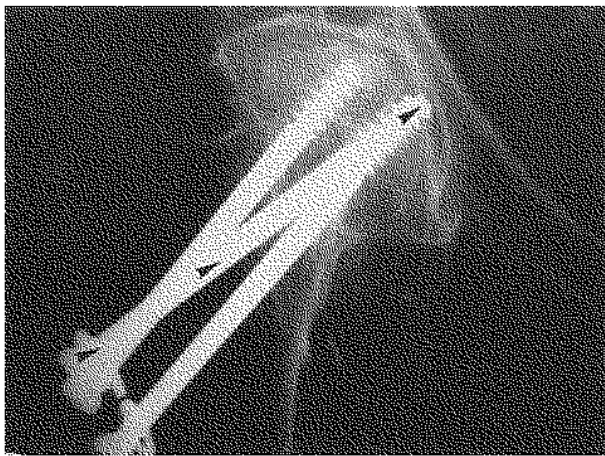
Radiograph of a 59-year-old woman 15 months after the SAP internal fixation. The bony union was solid 1 year after the fracture. Clinically the result was poor.
